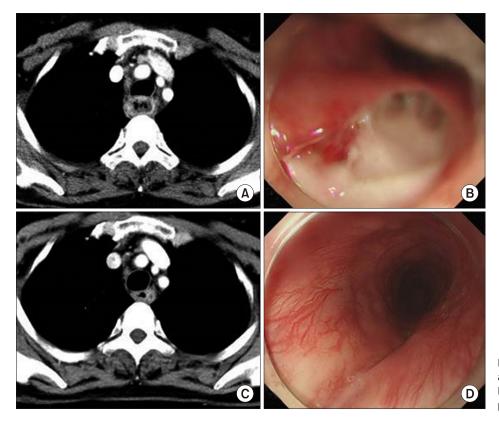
Computed tomography scan and endoscopic findings before (A, B) and after (C, D) treatment of phlegmonous esophagitis.
